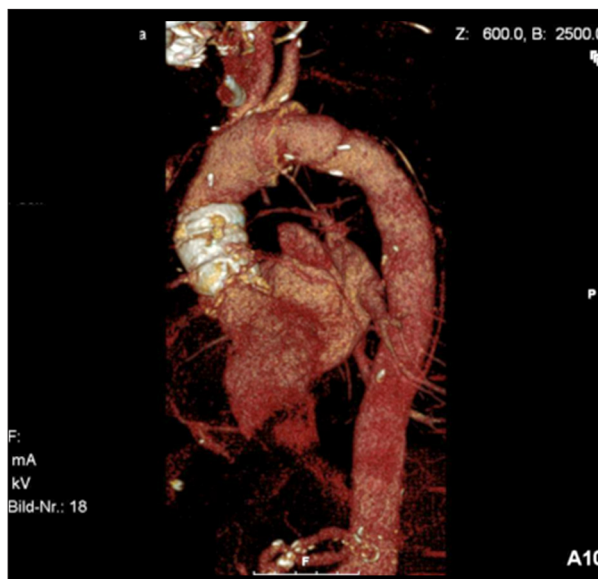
Multi-slice computed tomography of a 61-year-old female patient with a heavily calcified aortic homograft.
